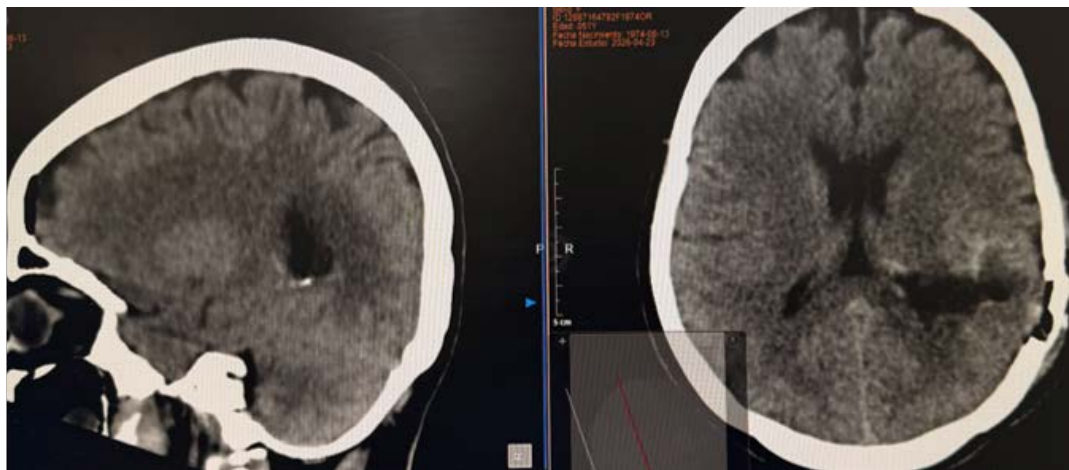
Postoperative control computed tomography (CT) images, including axial slices and sagittal reconstructions, confirming complete tumor resection without evidence of structural anatomical damage.
